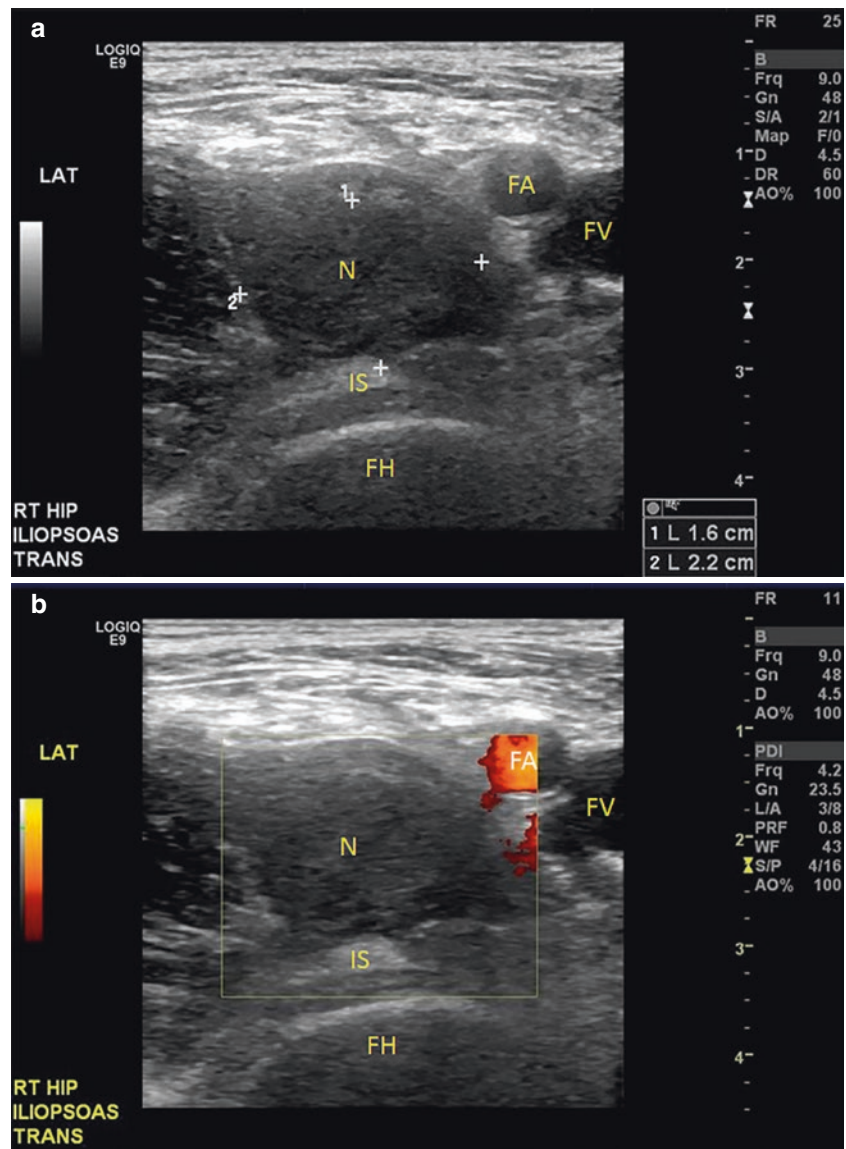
(a) Transverse image of the right iliopsoas (IS) at the level of the femoral head (FH) just distal to the iliopsoas tendon. There is a hypoechoic nodule (N, delineated by measurement calipers) intimately associated with the anterior margin of the iliopsoas tendon (IS); the nodule was pathologically proven to be a giant cell tumor of the tendon sheath. Left side of image is lateral. (b) The same image with power Doppler showing no discernible blood flow in the nodule, compared with the blood flow within the femoral vessels. FA femoral artery, FV femoral vein. (Images courtesy of Naveen Murthy)
